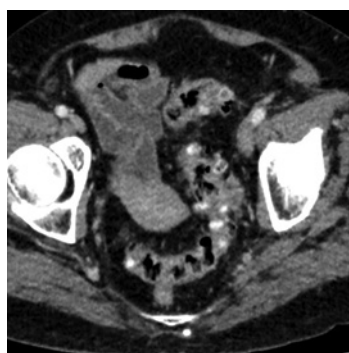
CT image in relapsing diverticulitis.
